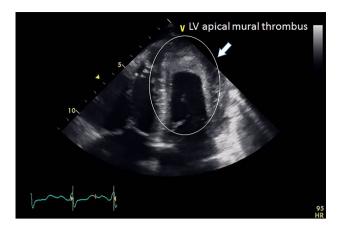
Preoperative transthoracic echocardiogram shows a large apical mural thrombus in the left ventricle (LV), reducing the size of the chamber
